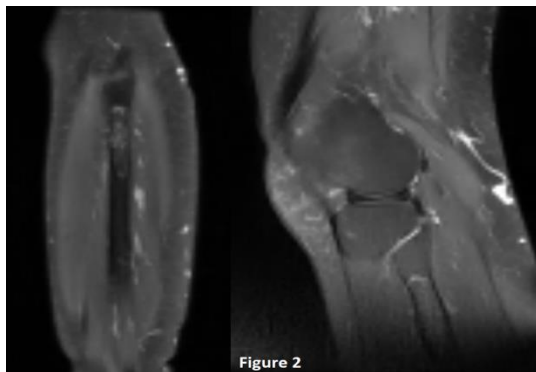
MRI of the left knee and the left fibula shows a lesional process of the upper metaphysis of the fibula with thinning of the cortex.
